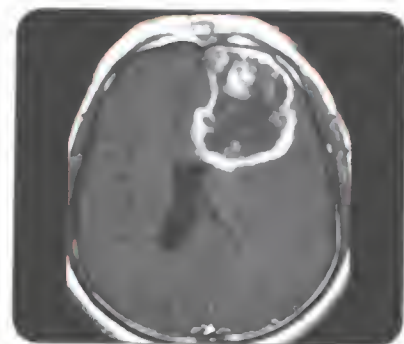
MRI brain showing glioblastoma multiforme. It is very aggressive malignant tumour.
